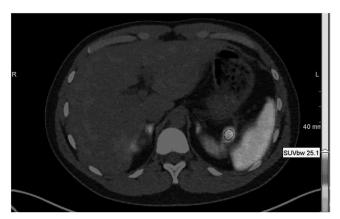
⁶⁸Ga-Dotatate PET/CT.
